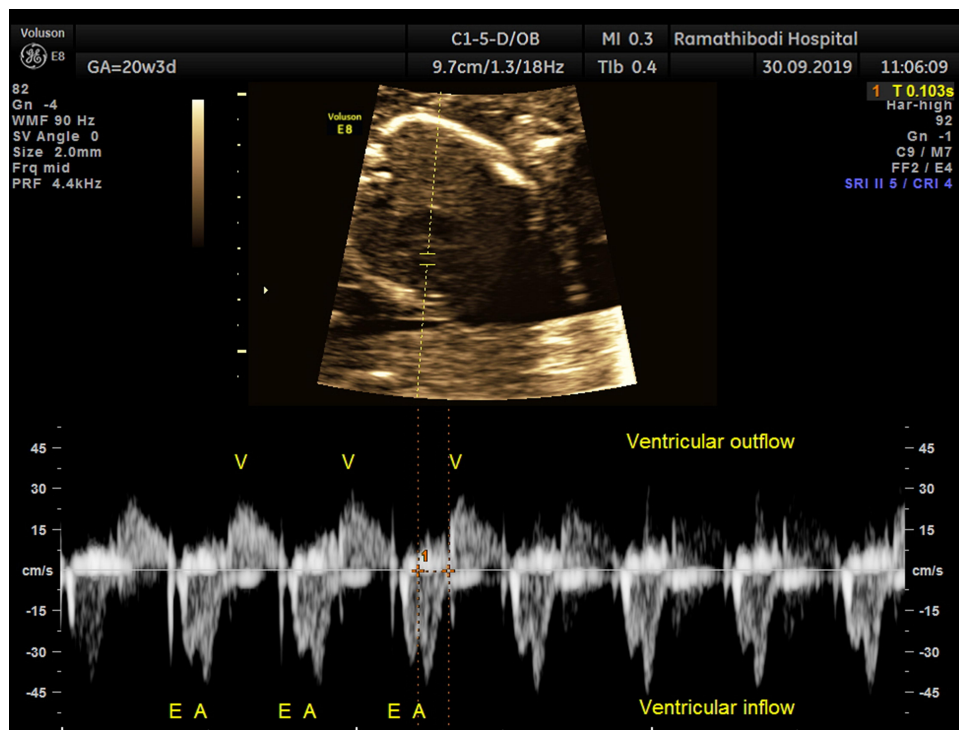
Pulsed wave Doppler image of mitral valve inflow–outflow view obtained from five-chamber view, time between atrial systole of mitral valve and onset of ventricular systole represents mechanical PR interval.
